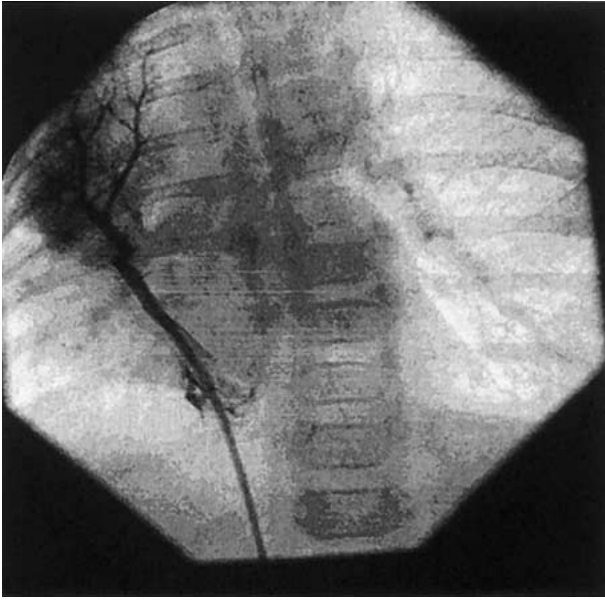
X-ray angiography AP projection. Injection in the right pulmonary vein reached from the inferior vena cava through the pulmonary veins collector.
